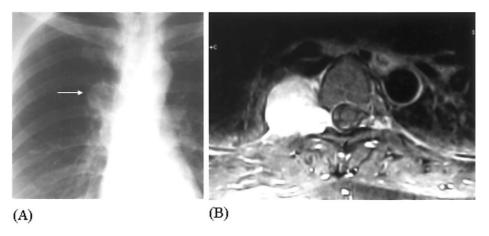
(A) Chest X-ray shows a mass at peri-hilar region of right lung. (B) The axial T1W enhanced MRI reveals a well-defined mass widening the right T6 intervertebral foramen and extending through the foramen into the paraspinal soft tissues. There is homogeneous enhancement with gadolinium.
